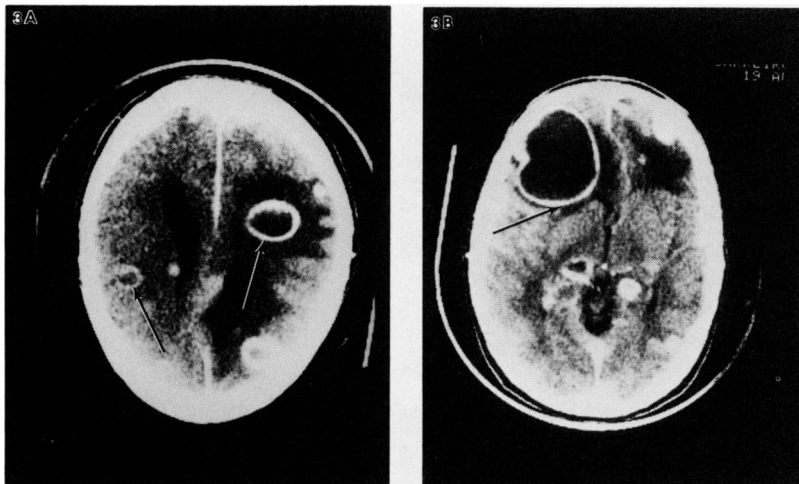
CT scans obtained during evaluation of patient No. 2 for possible brain abscess. A. Ring-enhancing lesions (arrows) are clearly demonstrated. B. Large right-sided ring-enhancing lesion causing shift of brain contents leftward. At biopsy of this lesion infection was not encountered. Lesions proved to be metastatic in origin.
